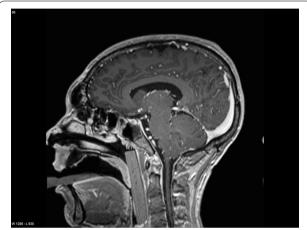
Magnetic resonance imaging of the brain showing the displaced gag (*arrow*)
